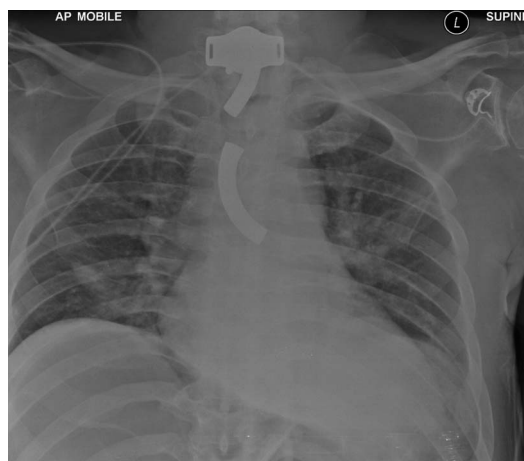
Chest X-ray demonstrating dislodged metal outer cannula resting in the left main bronchus. The metal base plate and remaining inner tube of the tracheostomy can also be seen.
